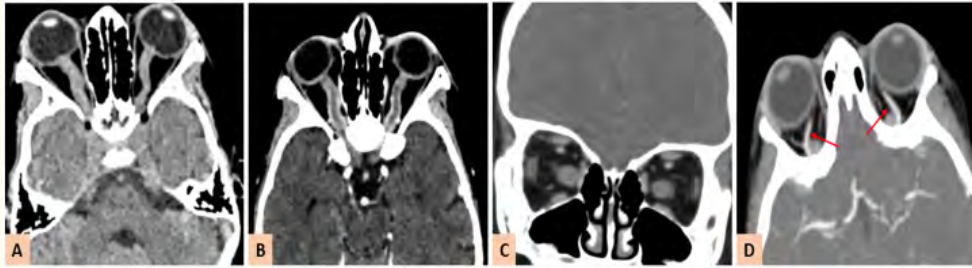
Cerebral CT scan. Axial CT scans without injection (A) and after injection (B) showing thickening and tortuosity of the optic nerves, which show contrast enhancement. The red arrows indicate correct opacification of the ophthalmic arteries.
